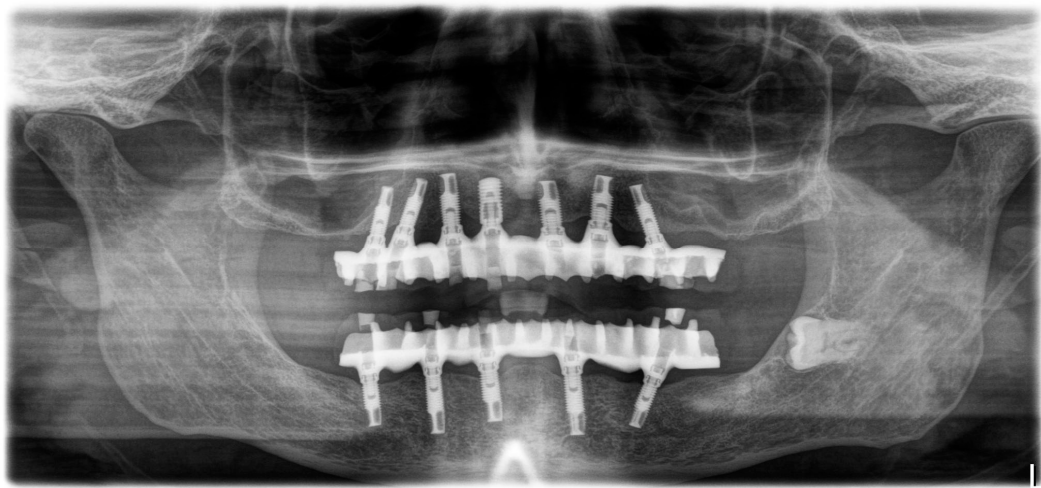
orthopantomogram (OPG), a seven-year follow-up after surgery.
